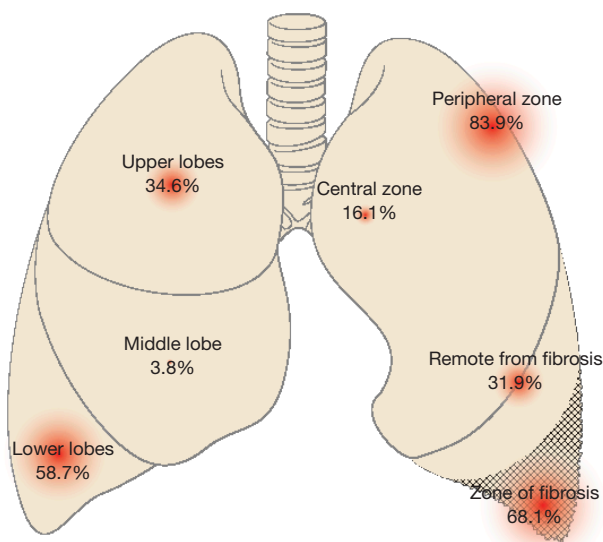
CT scan presentation of LC associated with ILD (see text). LC, lung cancer; ILD, interstitial lung disease; CT, computed tomography.
